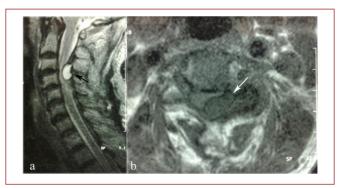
(a) Sagittal T2-weighted MRI showing compression of the spinal cord posteriorly at the C3–4 facet joint level by an intraspinal hyperintense cystic lesion (*black arrow*), (b) Axial T1-weighted MRI showing compression of the spinal cord extradurally from the left posterolateral area by the same hypointense cystic lesion (*white arrow*).
